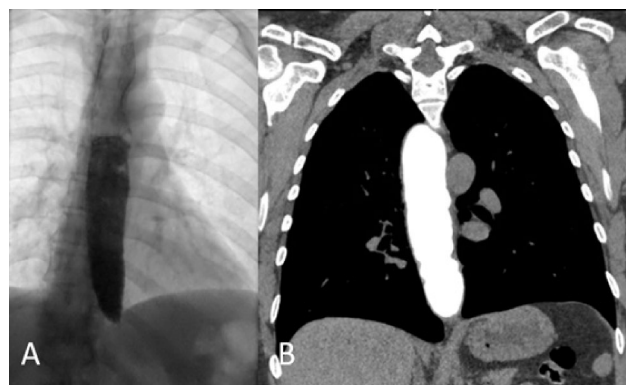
Contrast examination of the esophagus. Barium swallow (A) and computed tomography (B). Stop at the level of the GEJ with proximal dilatation of the esophagus
